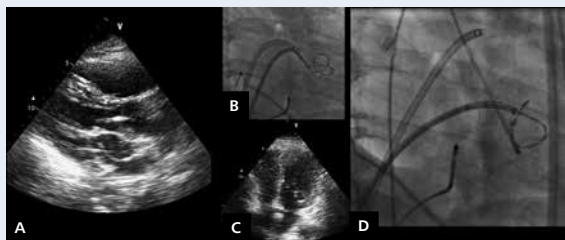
Entrapped circular mapping catheter. Transthoracic echocardiogram and fluoroscopy images (A–C) demonstrating circular mapping catheter entrapped in mitral valve apparatus. Unsuccessful attempt to free mapping catheter using pigtail catheter via retrograde aortic approach (D)
